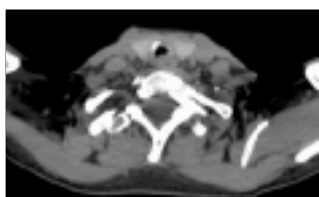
CT scan axial plane showing a tracheal narrowing.
